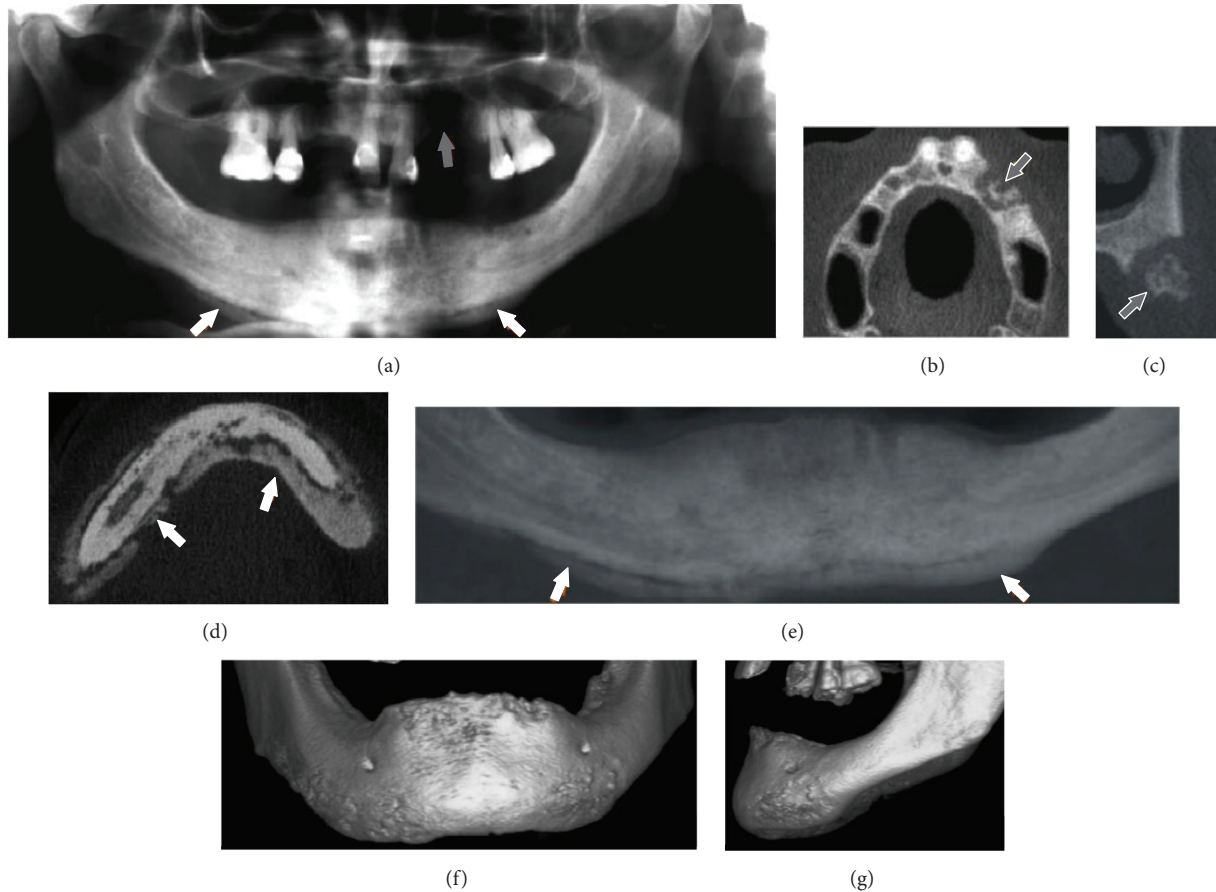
Imaging findings of a 57-year-old woman with metastatic breast carcinoma receiving intravenous zoledronic acid. (a) Panoramic radiograph showing maxillary involvement with radiographic evidence of osteolysis (gray arrow). (b) and (c) axial and cross-sectional CBCT views, respectively, showing the necrotic area with bone sequestrum in the left maxilla (gray arrow). (d) Axial CBCT image showing the extent of mandible bone involvement with periosteal bone reaction. The periosteal bone reaction changed the mandibular morphology, as it can be seen in the two-dimensional multiplanar reconstruction image ((e), white arrow) and in the 3D images (frontal view (f) and sagittal view (g)).
